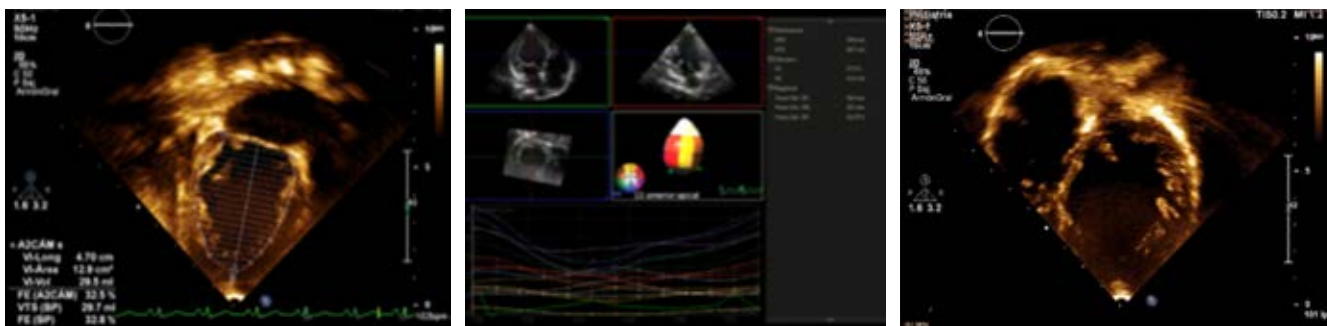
Echocardiogram performed before banding in March 2017: LVEF BP 32.8%; 3D 27.9%.
